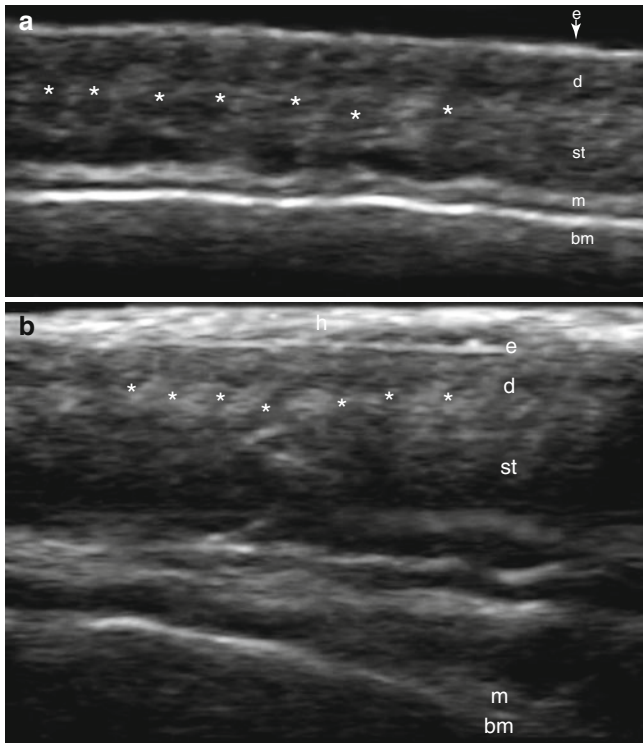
(a, b) Sonographic anatomy of the scalp (longitudinal views). Note in dermis the hypoechoic, oblique direction of hair follicles (*). (a) Frontal region. (b) Occipital region. Note increased thickness of subcutaneous tissue. Abbreviations: *h* condensed hair tracts, *e* epidermis, *d* dermis, *st* subcutaneous tissue, *m* epicranial muscle, *bm* bony margin of the skull
